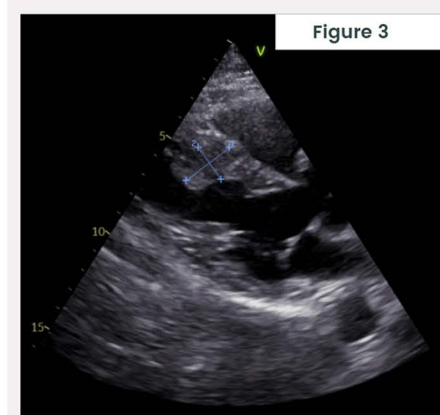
Appearance of the mass on modified apical four-chamber and parasternal long-axis views.
